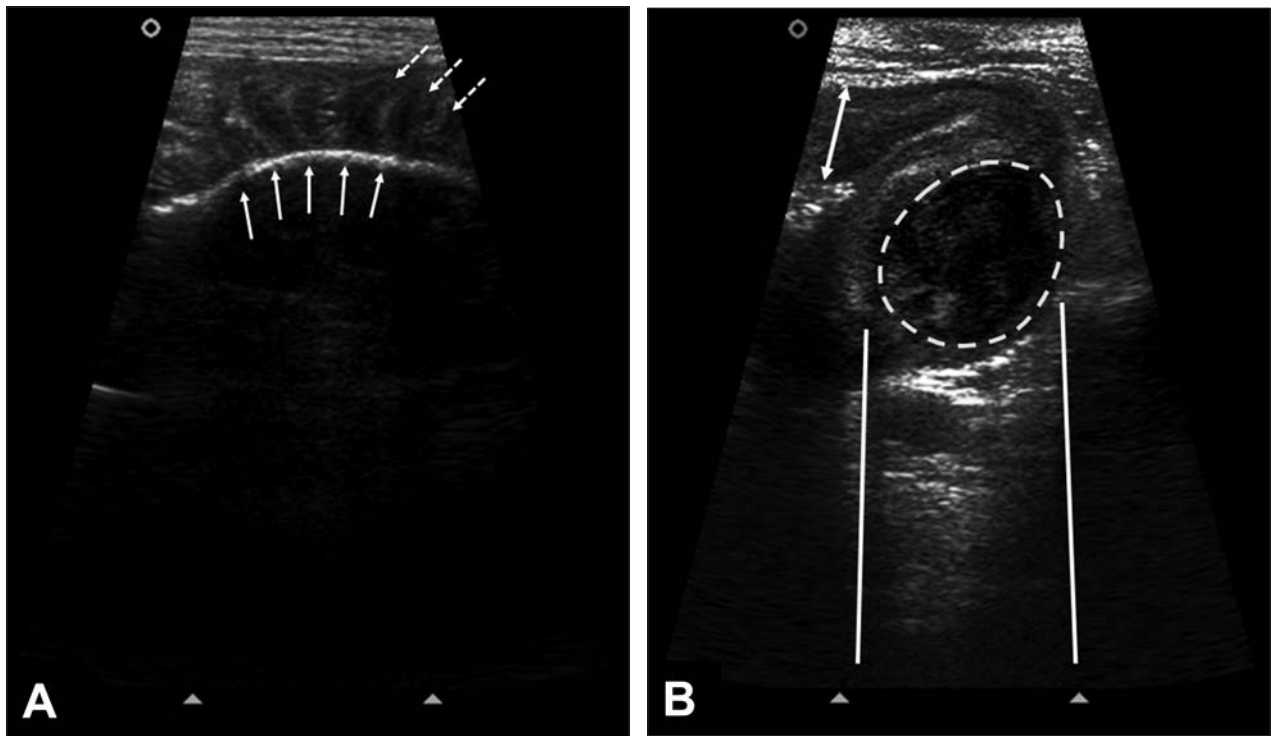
Same ultrasonographic images as in Figure 1. A—There is a linear hyperechoic interface in the intestinal lumen (solid arrows) casting an acoustic shadow, and intestinal plication is evident (dashed arrows). B—Notice that the intestinal wall is thick (double arrow). A hypoechoic heterogeneous circular structure (dashed line), associated with distal acoustic enhancement (solid lines), is evident and is located in the muscularis layer of the intestine.
